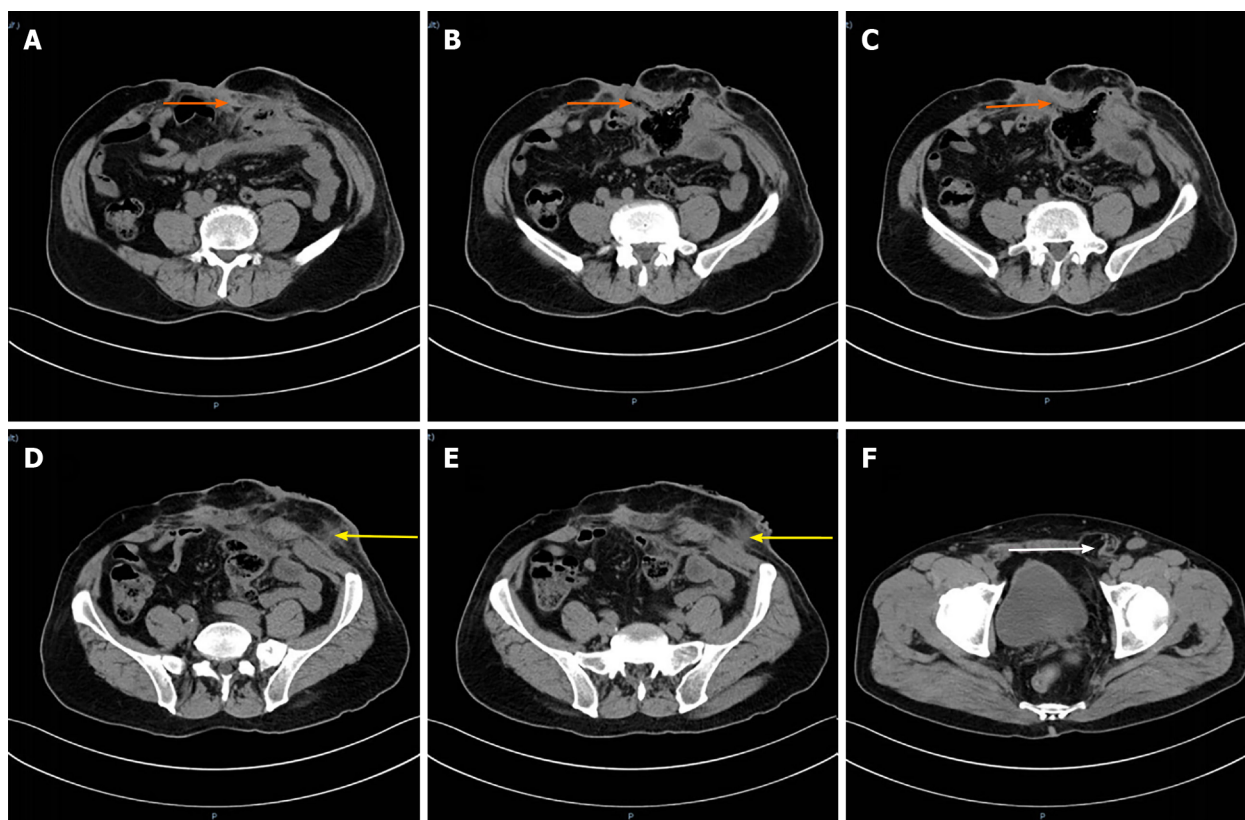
Enhanced computed tomography. A-C: The orange arrow refers to the sinus formed by the intestinal fistula on the right side of the stoma; D and E: The yellow arrow is the suspicious sinus on the left side of the stoma; F: The white arrow is the left inguinal hernia.
